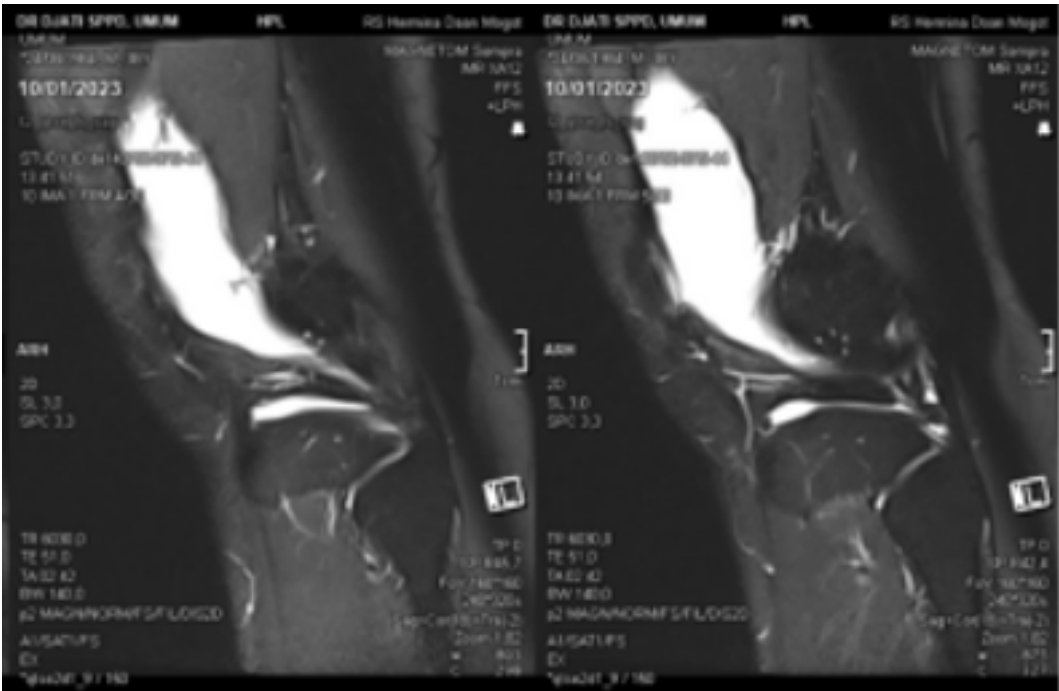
Sagittal MRI of the right knee showing a moderate fluid collection with hyperintense signal intensity at the posterior quadriceps tendon.
